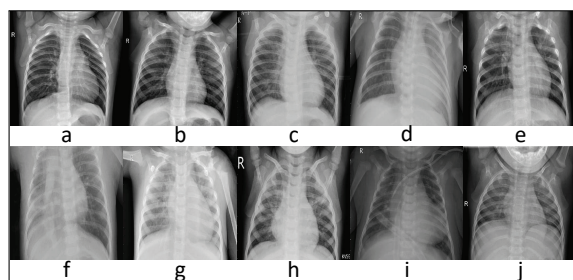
Examples of chest X-ray images classified using our method with corresponding confidence levels: (a) Normal, 100%, (b) Normal, 100%, (c) Pneumonia, 100%, (d) Pneumonia, 100%, (e) Pneumonia, 91.10%, (f) Pneumonia, 99.90%, (g) Pneumonia, 100%, (h) Pneumonia, 100%, (i) Pneumonia, 100%, and (j) Normal, 99.00%.
